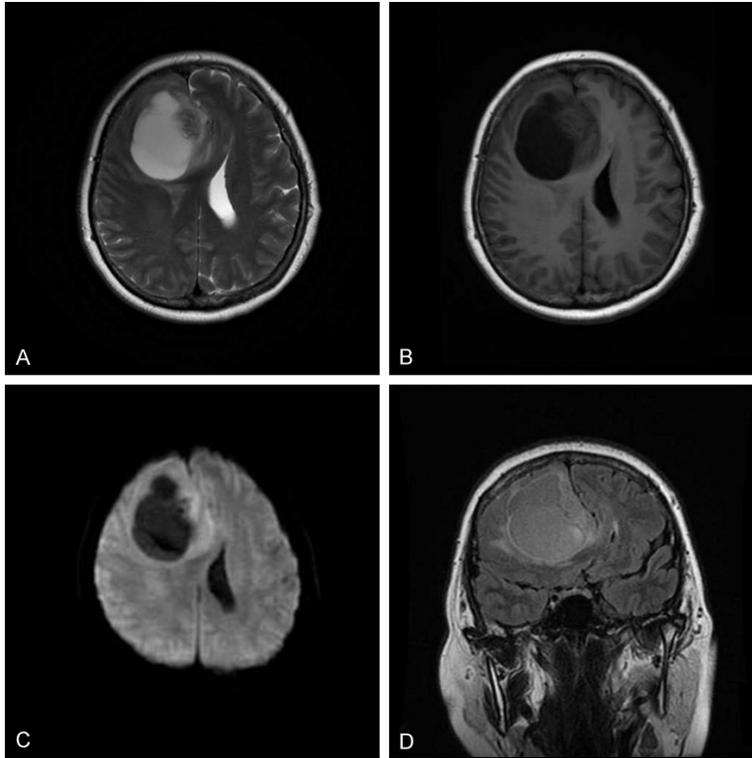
Magnetic resonance imaging (MRI) showed a solid cystic mass in the right frontal lobe with a range of 4.7 cm×5.6 cm. The solid part of the diffusion image showed a slightly higher signal, the cystic part showed low signal. The boundary was mostly blurred, and the edema signal was seen around. A. Axial, T2-Weighted. B. T1-Weighted. C. Diffusion weighted imaging (DWI). D. Enhanced magnetic resonance imaging.
